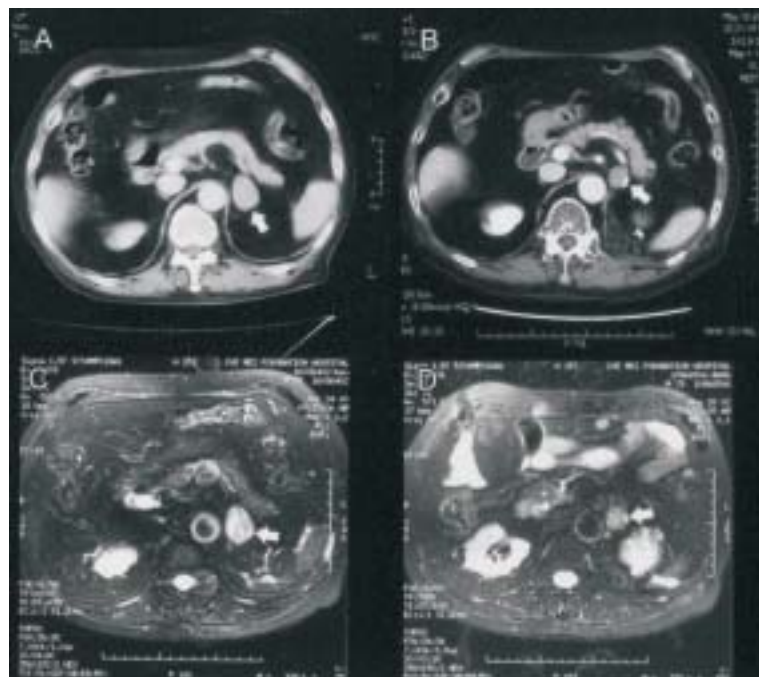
Computed tomography (CT) of the abdomen and pelvis without and with contrast enhancement shows: (A) a 3.0 × 2.5-cm soft tissue nodule at the left suprarenal region (arrow), compatible with adrenal tumor; (B) a 2 × 1-cm well defined soft tissue nodule with no obvious enhancement after contrast injection at the left suprarenal region (arrow), compatible with recurrent adrenal tumor. Magnetic resonance image (MRI) of the upper abdomen without and with intravenous Gd-DTPA enhancement shows: (C) a well-defined nodular lesion with high signal intensity in T2WI in left adrenal gland (arrow); (D) a nodular lesion shows intermediate signal intensity in T2WI in the left adrenal gland (arrow).
